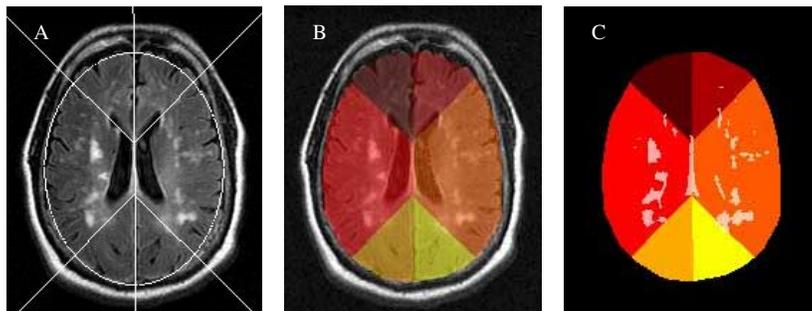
Definition of the anatomical regions on a FLAIR slice. An ellipse is fitted on the brain ROI (A). The medial axis of the smallest rectangle including the ellipse was then computed allowing the delineation of 8 regions. In B, 6 regions were defined on the ROI: left and right sides for the frontal (the 2 darkest ones), temporal (the 2 intermediate ones) and parieto-occipital (the 2 brighter ones) regions. The WMC segmentation corresponding to slice A is shown on C. The WMC volume could be computed on each region to assess its spatial distribution. The same protocol was used for the IR-FGE and for the perfusion maps.
